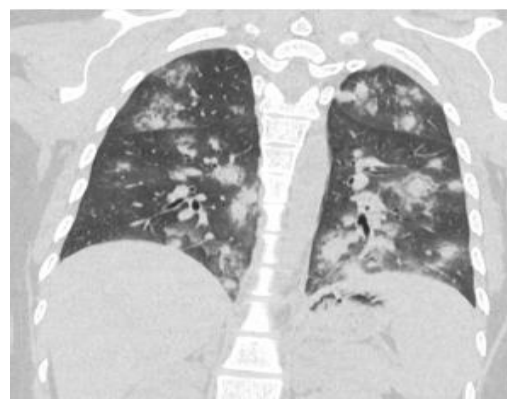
HRCT Thorax – Coronal view: bilateral multifocal consolidations with extensive surrounding
